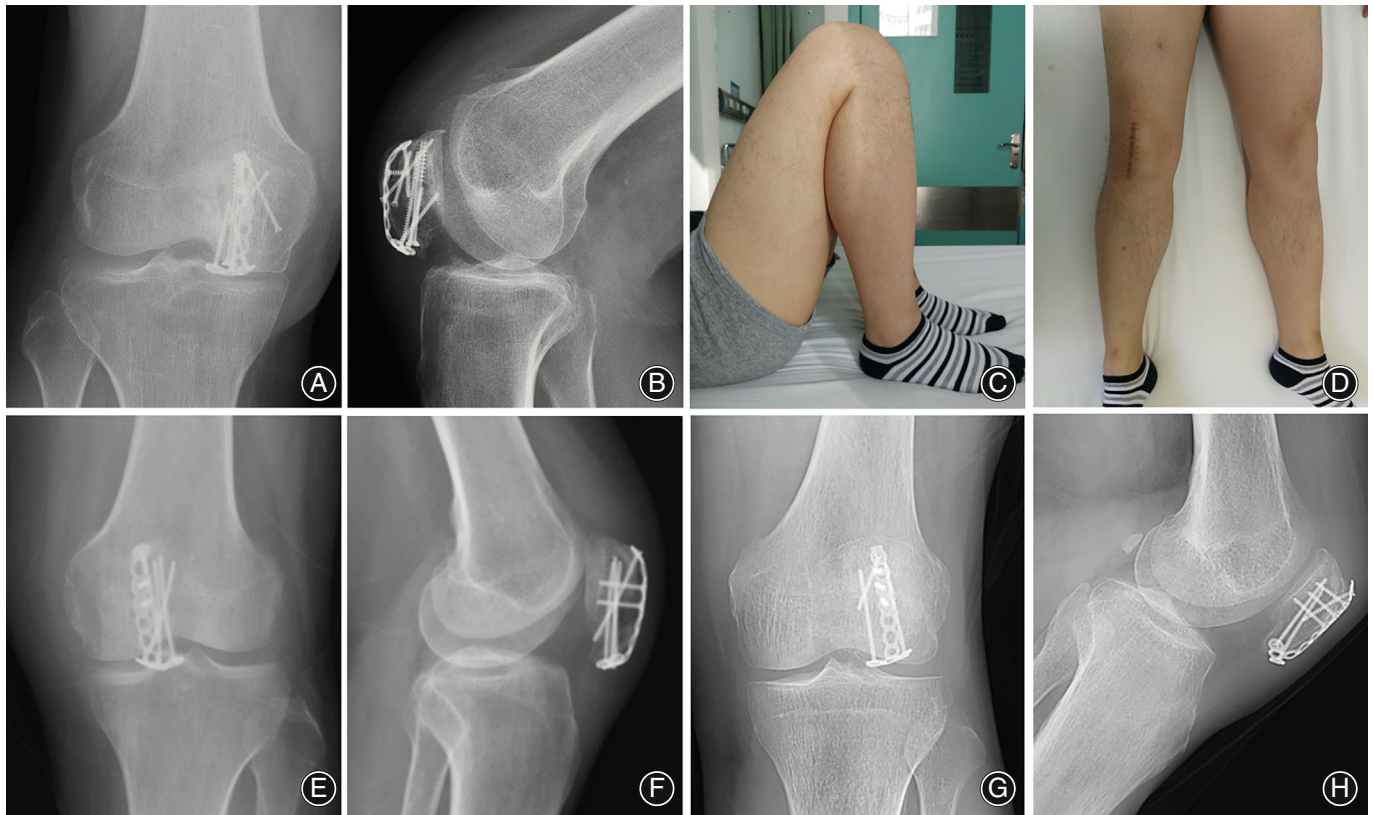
The follow-up at 12 months post operation. (A) Anteroposterior and (B) lateral X-ray images showing good bone healing and implant position of Patient 1. Maximum of (C) extension and flexion (D) of knee joint showing fully recovered range of motion (0–140°) of Patient 1. (E) Anteroposterior and (F) lateral X-ray images showing good bone healing and implant position of Patient 5. (G) Anteroposterior and (H) lateral X-ray images showing good bone healing and implant position of Patient 25.
